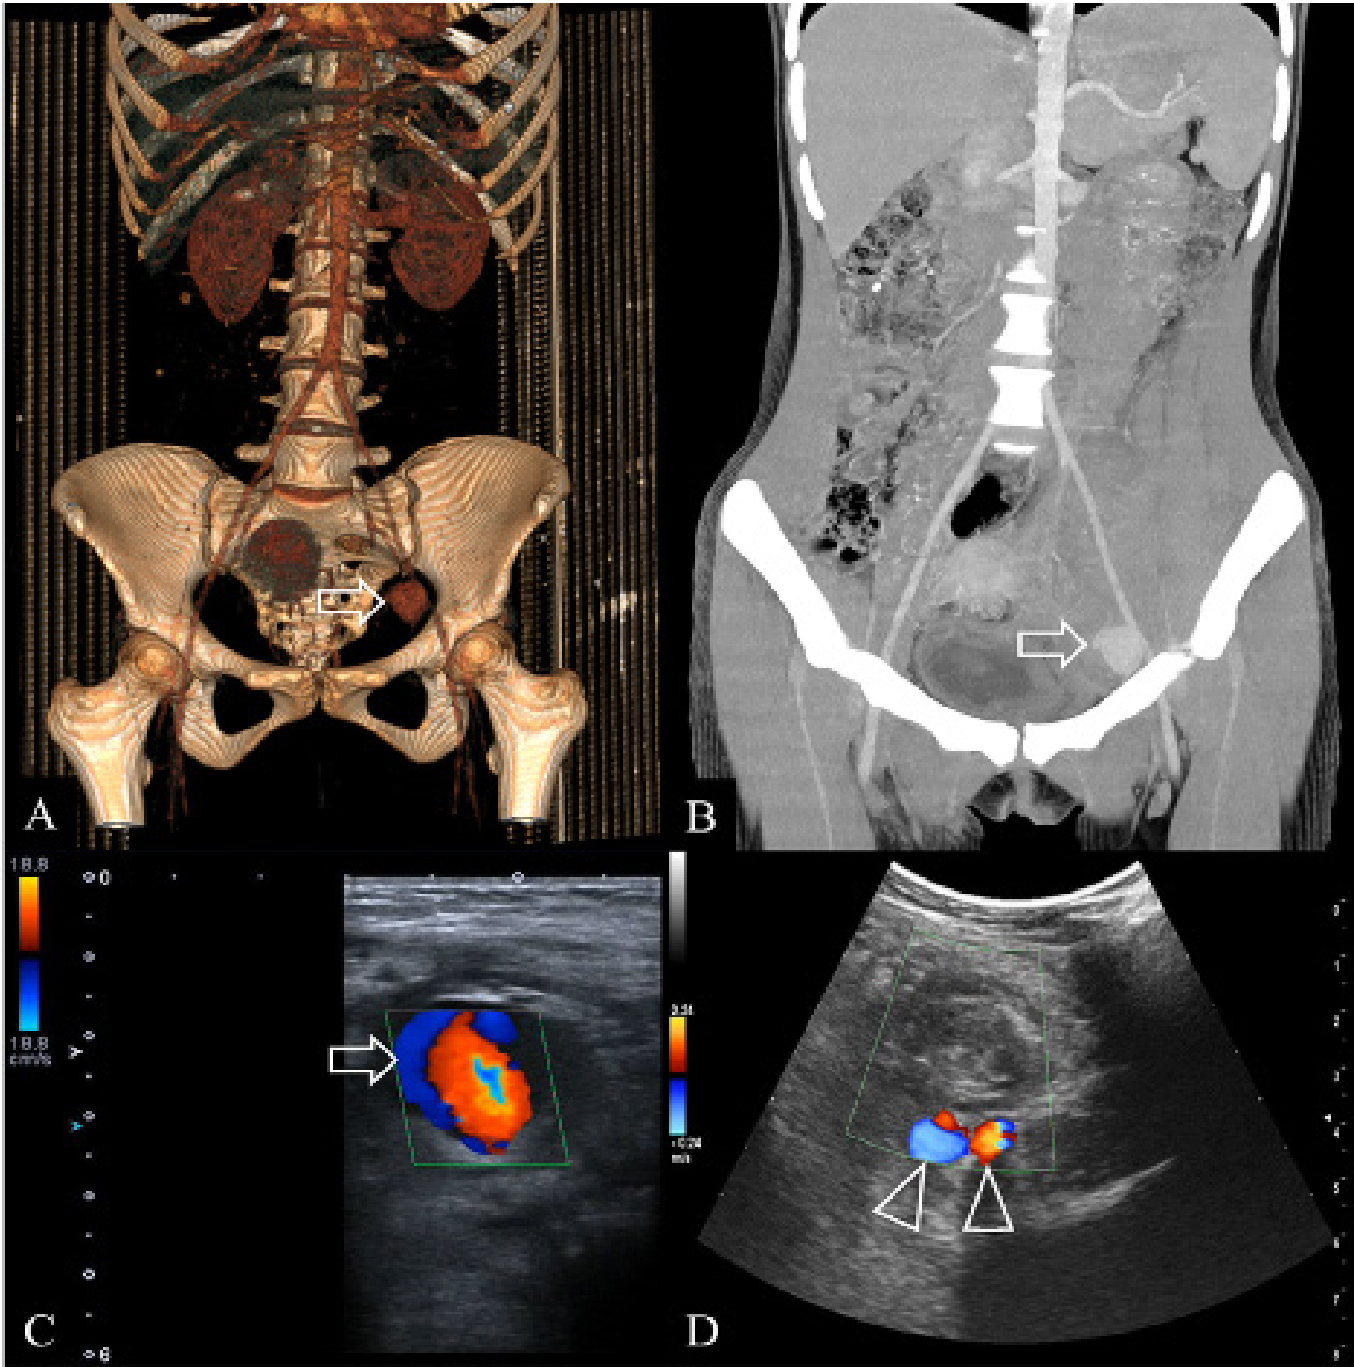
Imaging findings of left external iliac artery pseudoaneurysm. (a): 3D volume-rendered CT angiography demonstrates the pseudoaneurysm (white arrow) arising from the left external iliac artery. (b): Coronal MIP CT image shows the pseudoaneurysm (white arrow) and its anatomic relationship with adjacent vascular structures. (c): Pre-treatment color Doppler USG image demonstrates the characteristic “yin-yang” flow pattern within the pseudoaneurysm (white arrow). (d): Doppler USG image shows complete thrombosis of the pseudoaneurysm (white arrow) after USG-guided thrombin injection with preserved flow in the external iliac artery and vein (arrowhead).
